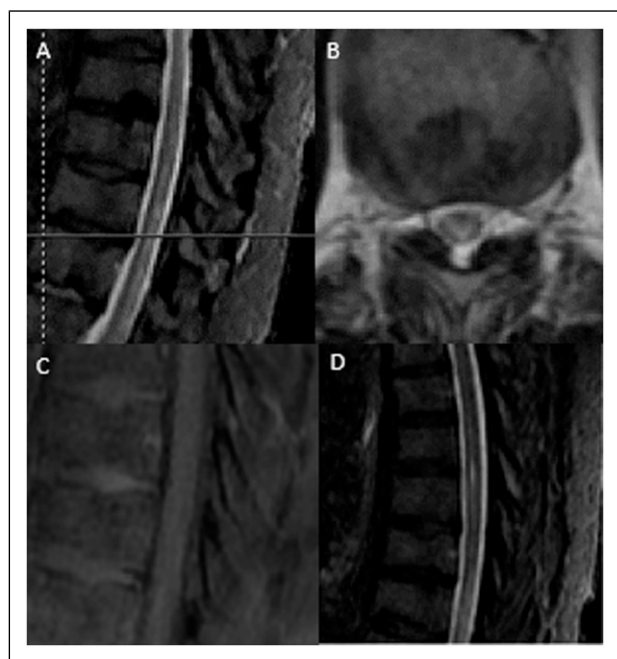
Thoracic spine MRI with 5-mm thickness slices. A. Sagittal STIR with longitudinally-extensive, T2-weighted hyperintense signal from T8 to T12 level. B. Axial plane at the level of T9/T10 demonstrating the same T2-weighted hyperintense signal. C. T1 sagittal post-contrast demonstrating no contrast enhancement in the region where the T2-weighted hyperintense signal was previously appreciated. D. Sagittal STIR revealing incidental syrinx located at T5-T8 level.
